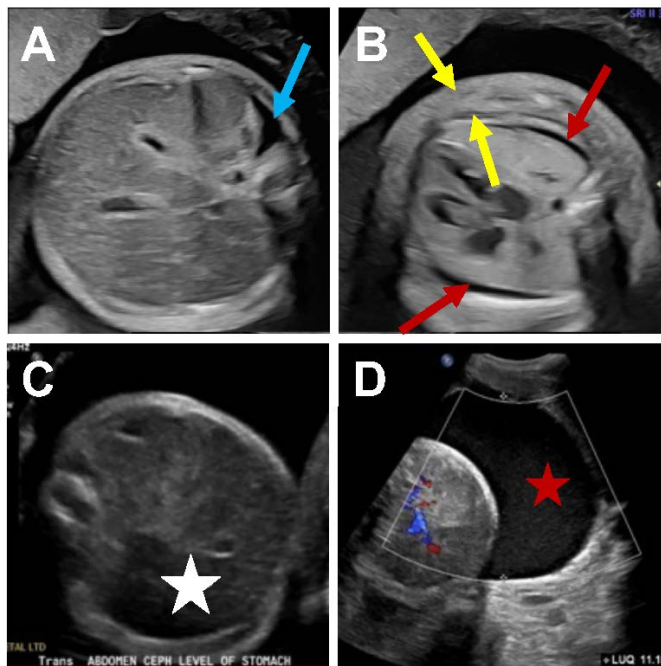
Ultrasound of the fetus in the vignette demonstrating fluid collections (blue, yellow, and red arrows and red star) and an absent stomach (white star in the usual location of the stomach). Adapted from Layoun V, Kim A, Edwards E, Feist C, Dukhovny S. *Neoreviews*. 2022;23(4):e284–e290. 10.1542/neo.23-4-e284¹
